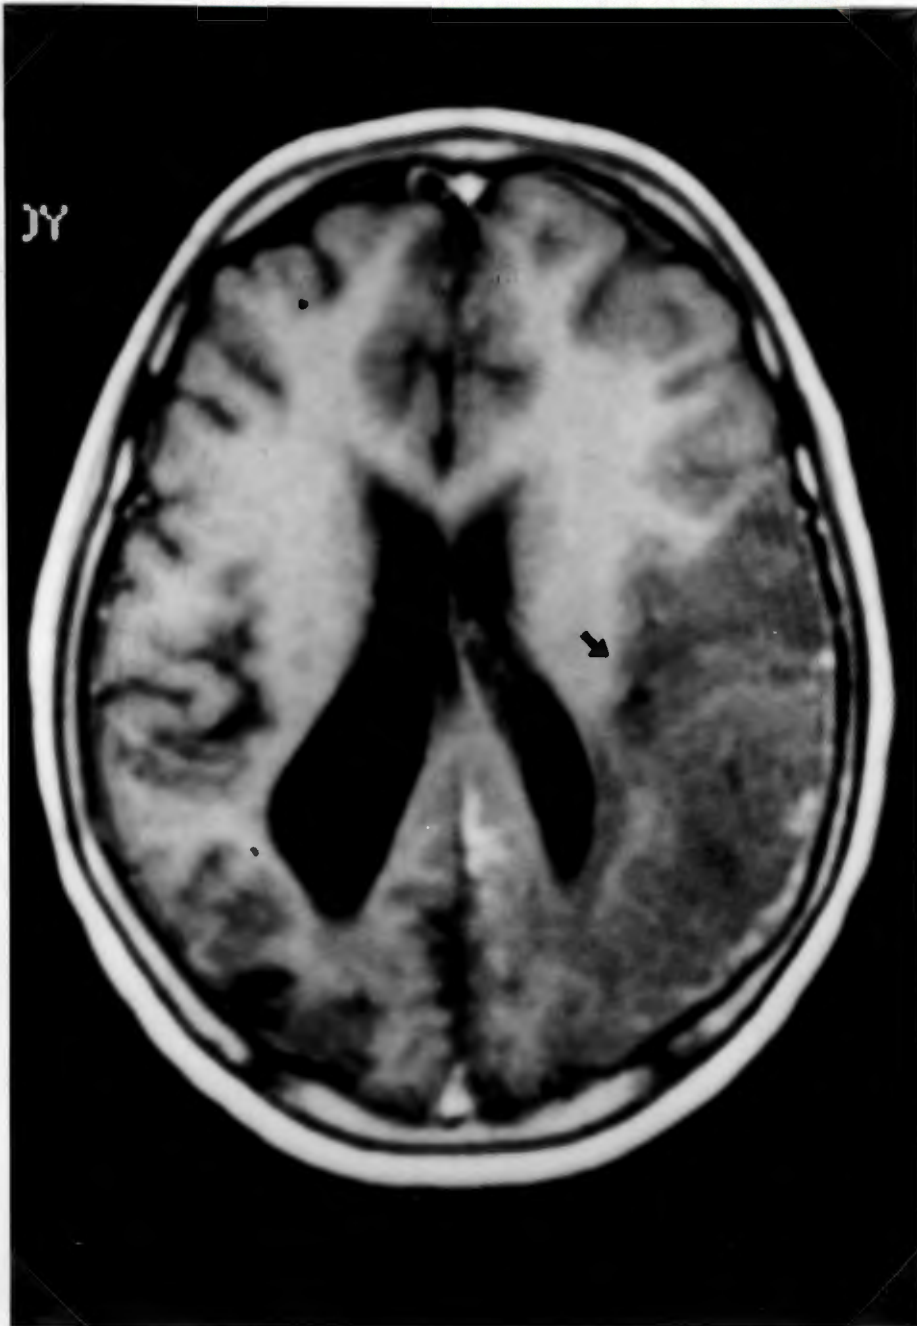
MRI scan of patient 31 (MELAS syndrome) demonstrating low intensity signals in the left parietal and both occipital lobes. Atrophy of the right occipital lobe is present with ex vacuo dilatation of the posterior horn of the right lateral ventricle.
